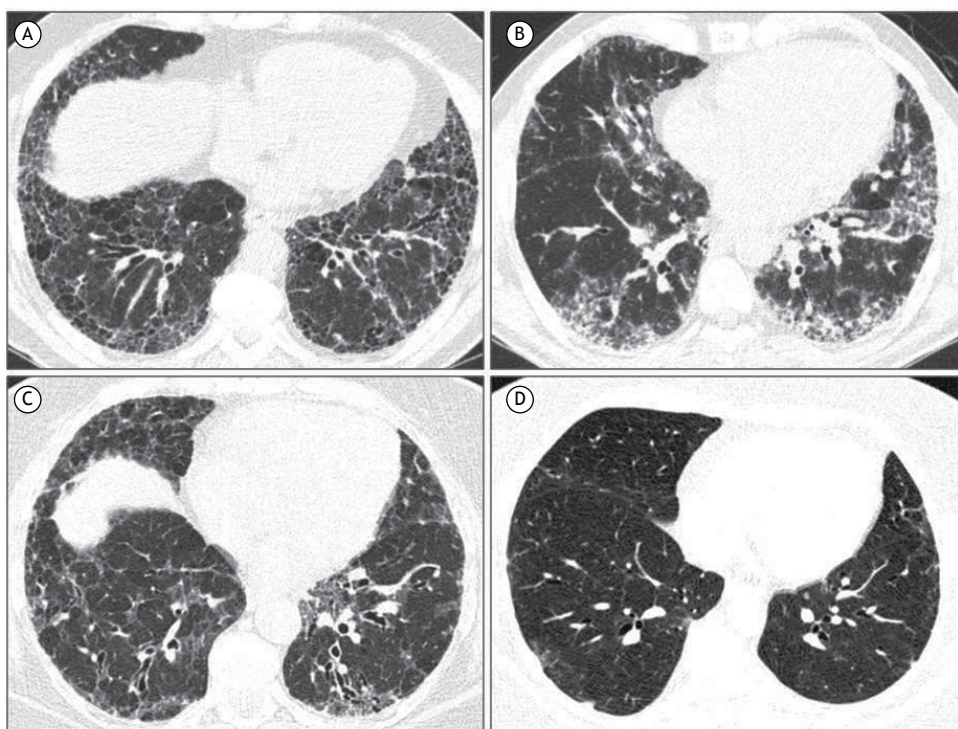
Axial HRCT scans (lung window) of patients with familial pulmonary fibrosis. In A, CT findings consistent with typical usual interstitial pneumonia. In B, CT findings consistent with a diagnosis other than idiopathic pulmonary fibrosis, i.e., consistent with nonspecific interstitial pneumonia. In C, CT findings consistent with a diagnosis other than idiopathic pulmonary fibrosis, i.e., consistent with chronic hypersensitivity pneumonia. In D, CT findings consistent with indeterminate usual interstitial pneumonia.
